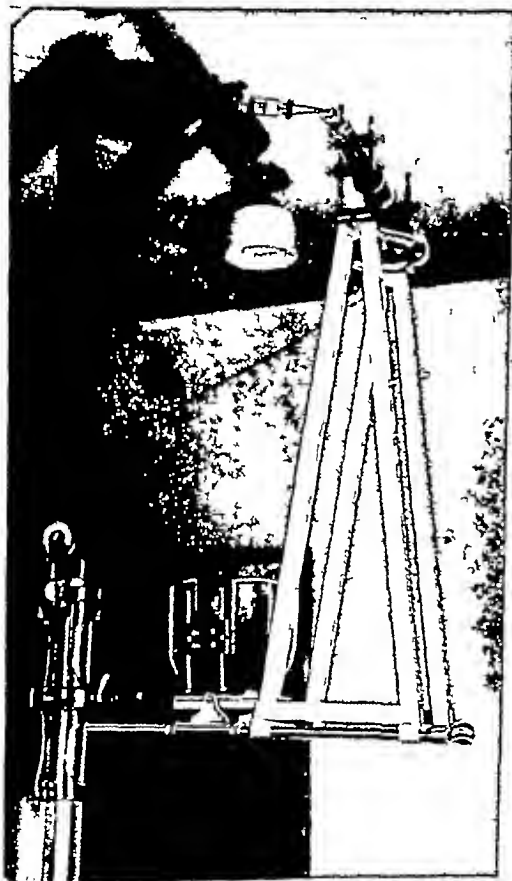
Showing device mounted upon the stand and cross arms swung out away from radiographic table to allow the bed to be wheeled alongside the table beneath the tube. Note the wooden rod with hook over high tension wire to anode which prevents spark jumping to near by high tension tubular conductor. Also note lead diaphragm and glass filter beneath tube stand of the device. The entire weight of the attachment is approximately four pounds. Base of device is firmly fastened to the cross-arms of tube stand by means of hook and eyes which are attached to the lower four corners of the device.
